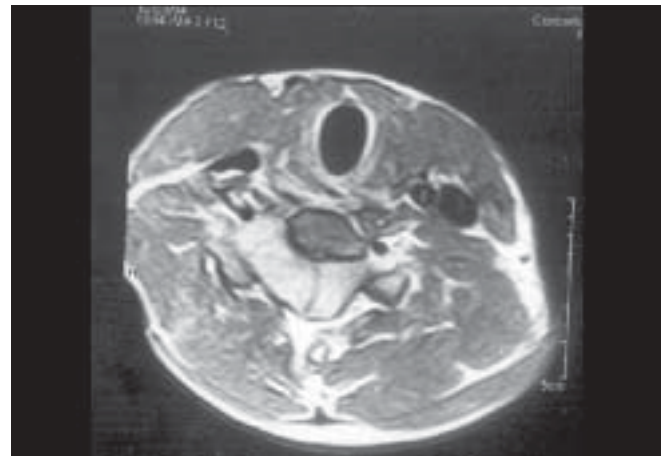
T1 weighted axial view of MRI at C₂ level showing right-side lateral dumbbell tumor displacing the cord to the left side and vertebral artery anterolaterally
